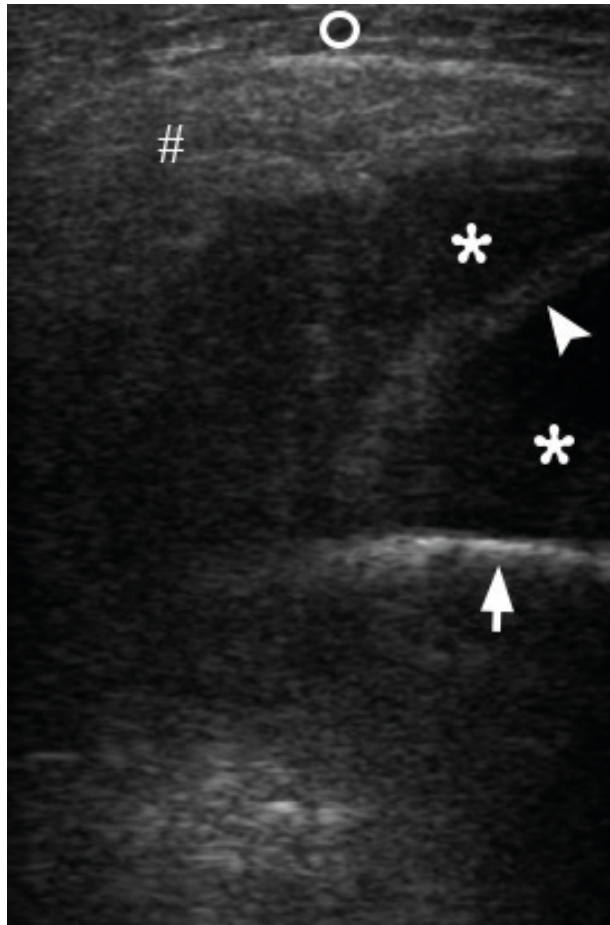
This transverse gray scale sonogram shows a collection of significant amount of anechoic fluid (*asterisks*), i.e., purulent content, between outer surface of the mandibular ramus (*arrow*), fibers of masseter muscle (*arrowhead*), right parotid gland (*hashtag*) which displaced by a collected pus. Subcutaneous tissue is labeled by *circle*. Printed with permission and copyrights retained by O.S.C. and I.I.F.
